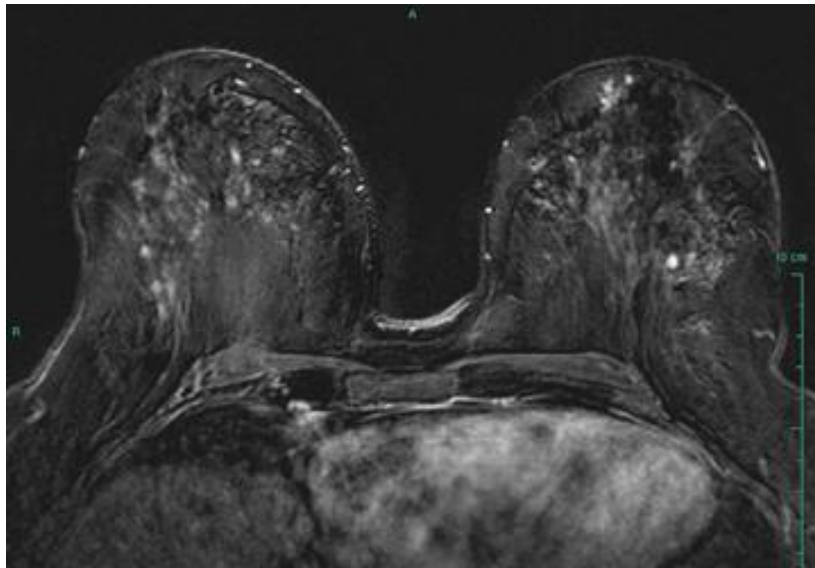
A Breast MRI with False Positive Nodule (Image courtesy: Radiological Society of North America)
